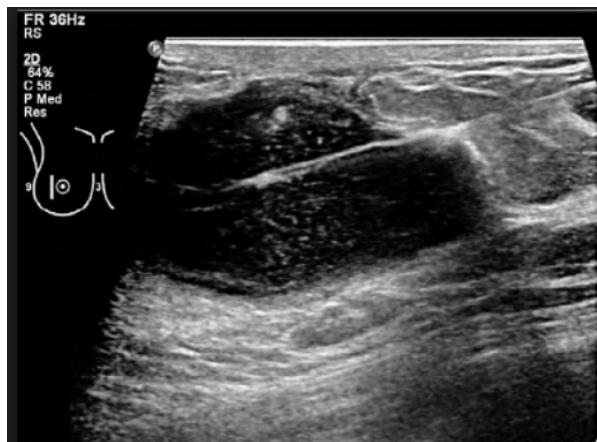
Ultrasonographic aspiration of breast abscess.
